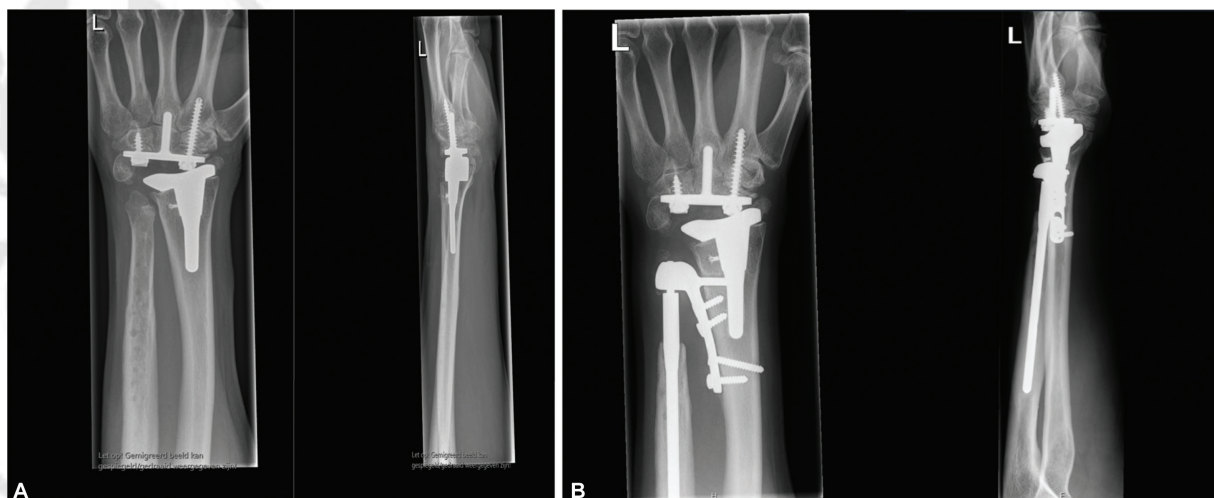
(A) Lateral and anteroposterior X-rays of case 2 before and after Aptis distal radioulnar joint (DRUJ) implantation. (B) Lateral and anteroposterior X-rays of case 2 after Aptis DRUJ implantation.
